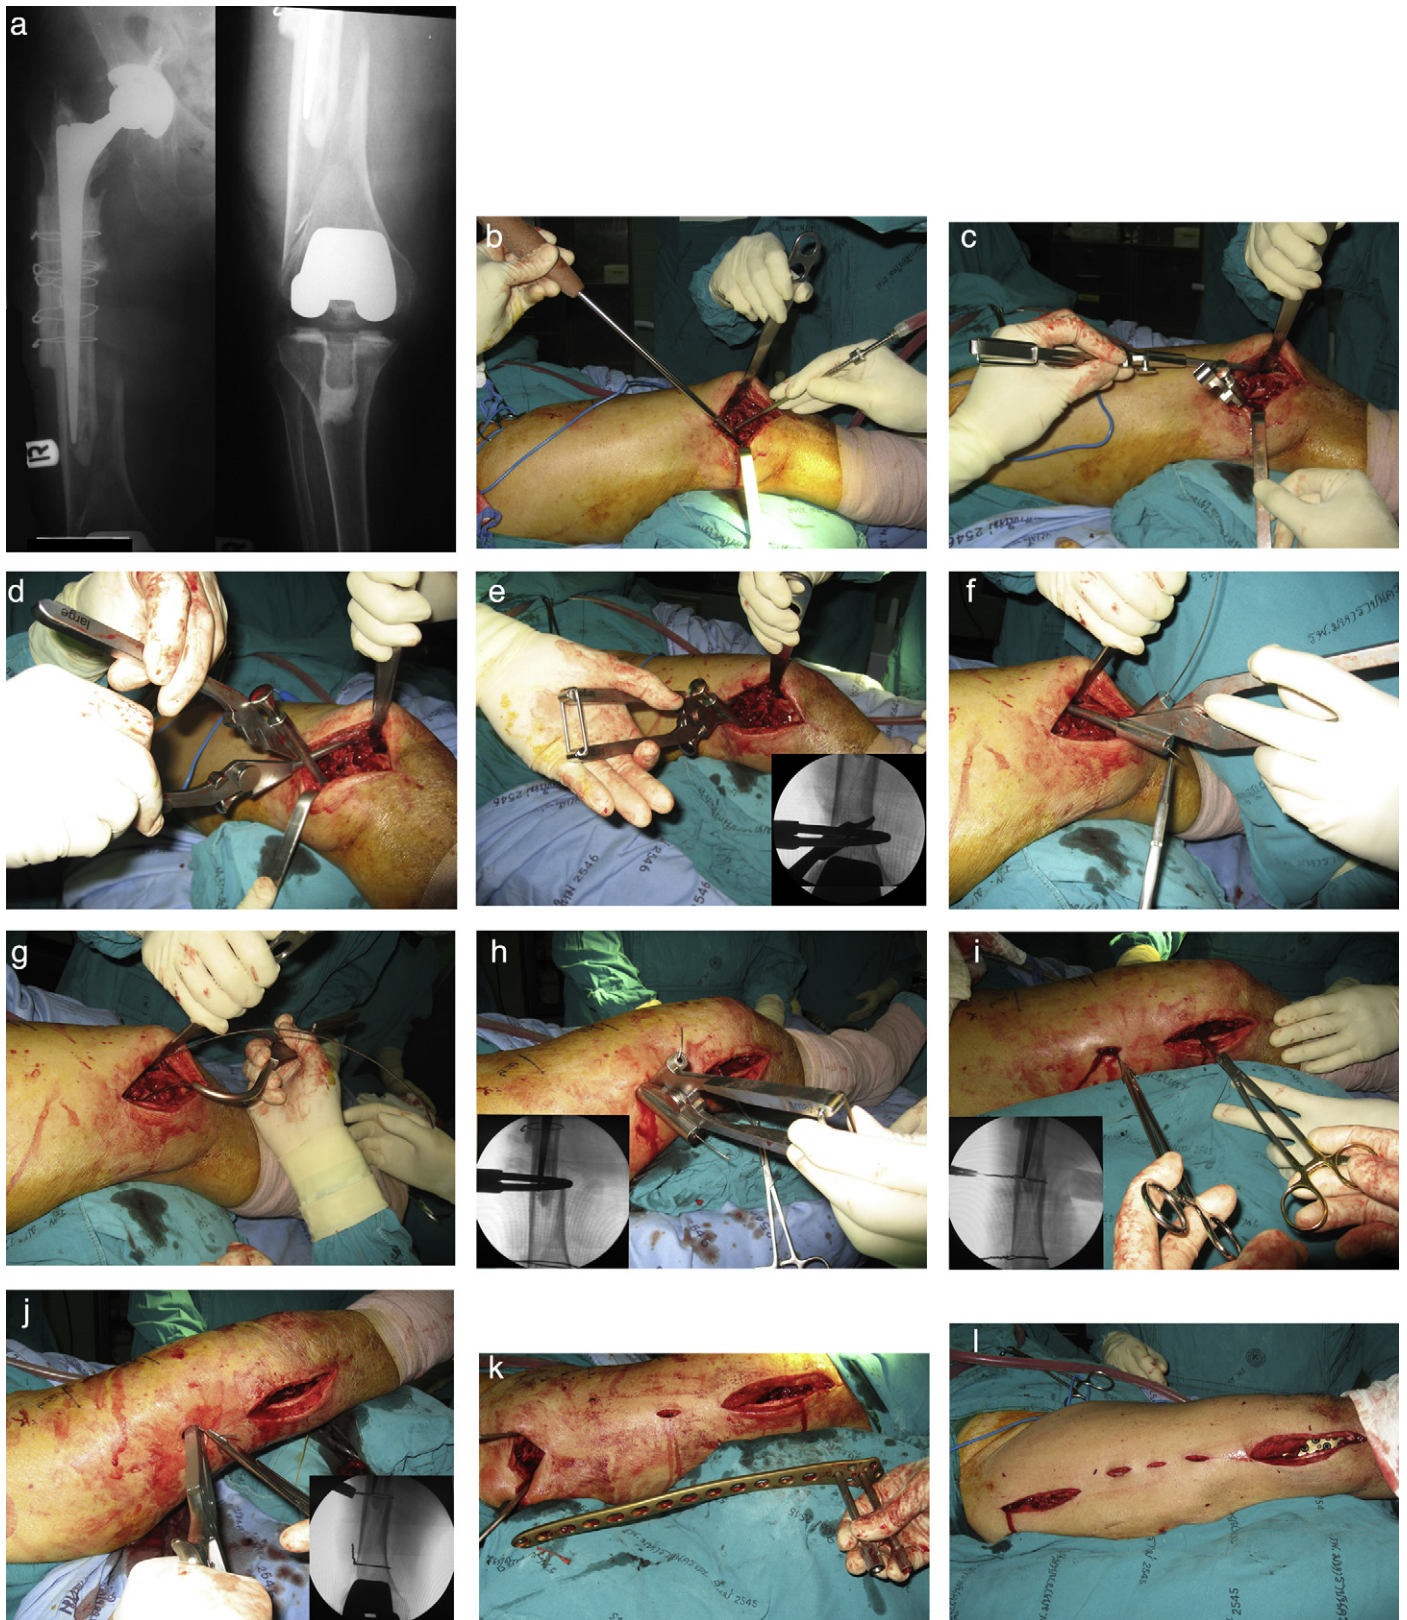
(a) An 84-year-old woman sustained a periprosthetic femoral fracture below the hip prosthesis and above the knee prosthesis. (b) The tunnelling device passed dorsally through the intermuscular septum on the linea aspera. (c) The cerclage passer passed dorsally and ventrally at the distal part of the fracture. (d) The flat middle parts of the forceps were connected. (e) The tips of the forcep were closed and demonstrated by image intensifier. (f) Passing the wire through the tube until it come out the opposite side. (g) Remove the cerclage passer from both sides; the first wire loop was loosely tightened. (h) The cerclage passer being inserted through the second incision. (i) Tightening the wire loop to reduce the fracture. The X-rays showing the reduction of the fracture with the wire. (j) The wire was bent and cut with the percutaneous wire cutter. (k) The distal femoral LCP was inserted from the distal incision towards the proximal incision. (l) The incisions after complete fixation of the fracture. (m and n) The X-rays demonstrated the fracture healed after six months with a good clinical outcome.
